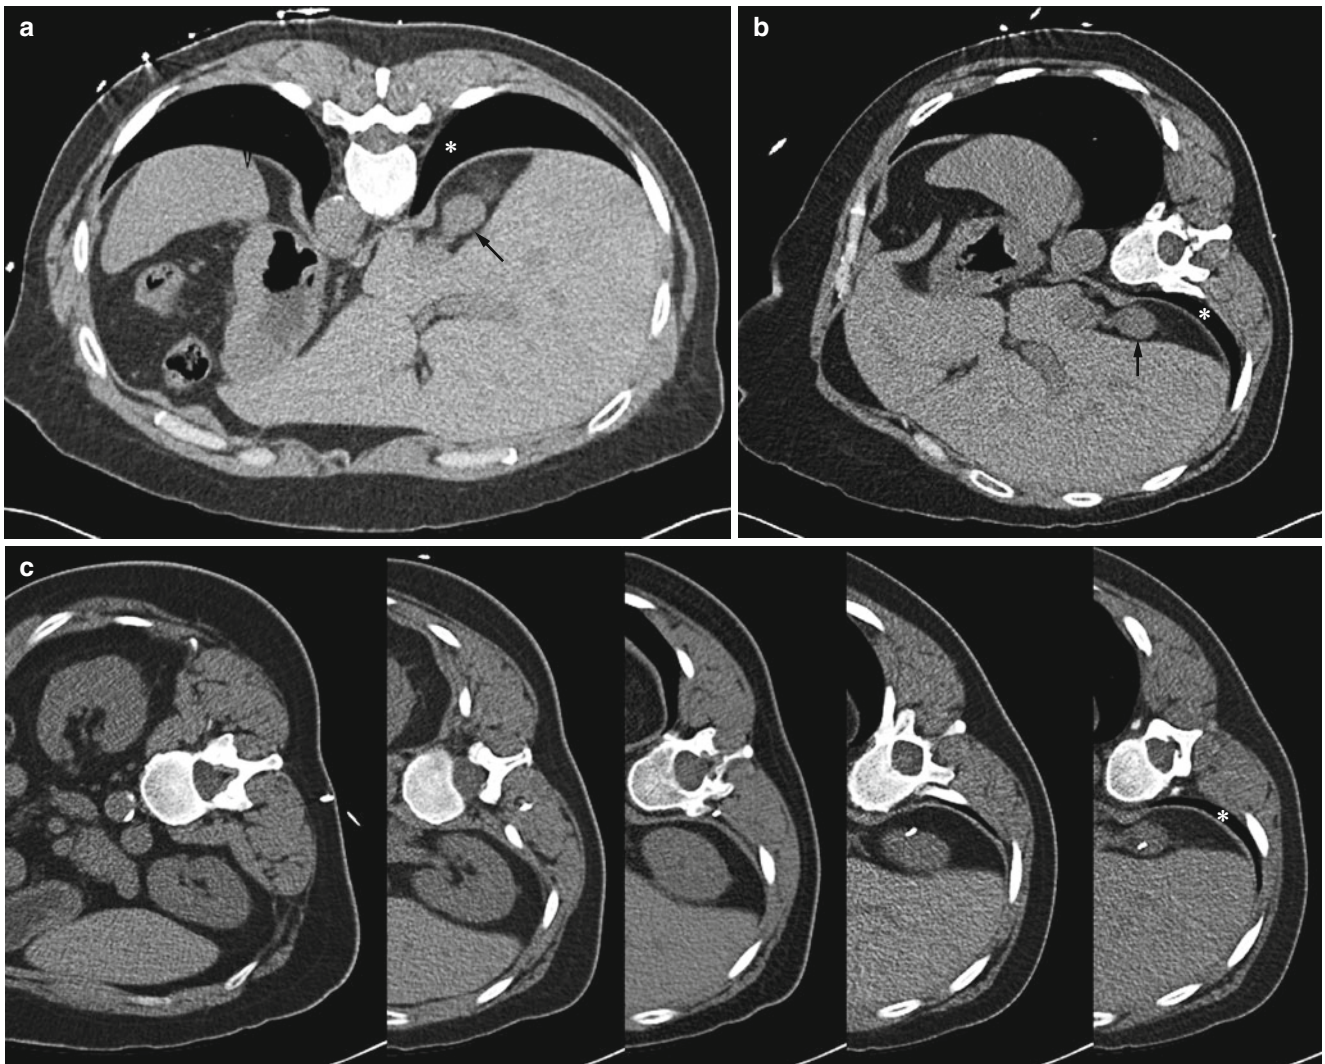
A 56-year-old woman with history of melanoma was referred for a biopsy of right adrenal gland. Axial CT image of the abdomen in prone position (a) shows the adrenal mass (arrow). Intervening lung parenchyma (asterisk) precludes safe needle insertion in this position. Often placing the patient in the ipsilateral decubitus position helps decrease the lung volume and provides a safe path for
